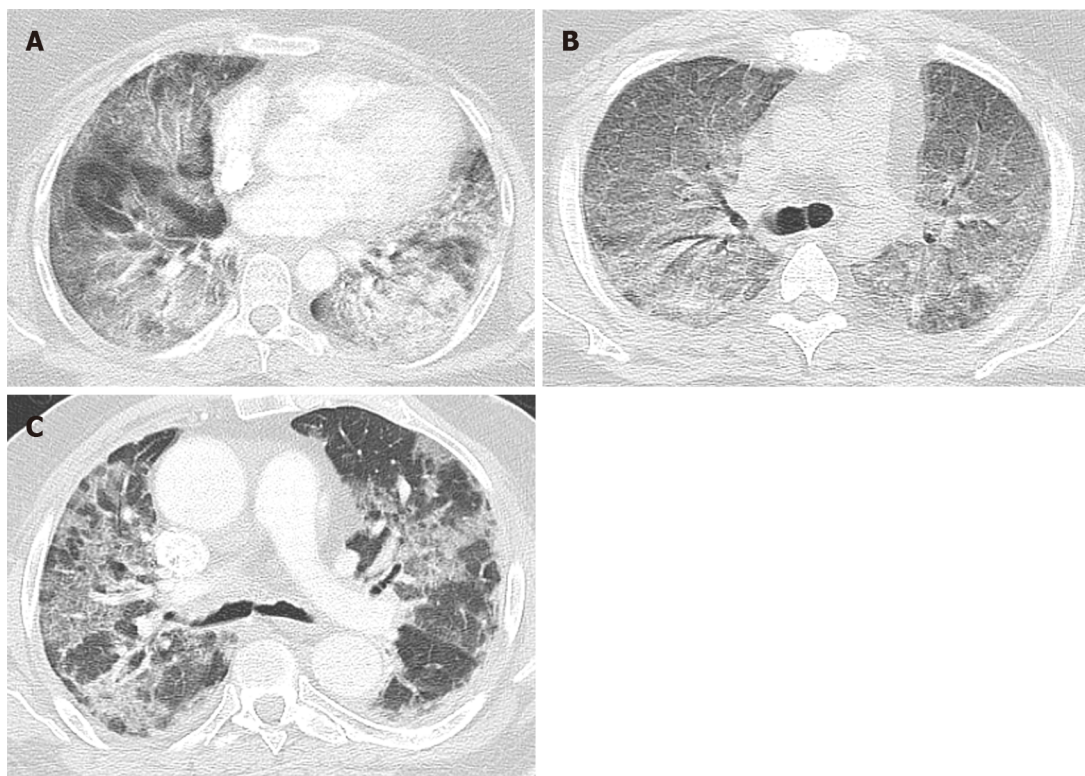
Computed tomography of the chest in acute exudative phase of acute respiratory distress syndrome in coronavirus disease 2019 patients. A: Bilateral diffused patchy density with ventro-dorsal gradient of density; B: Bilateral ground-glass opacity; C: Crazy-paving pattern.
